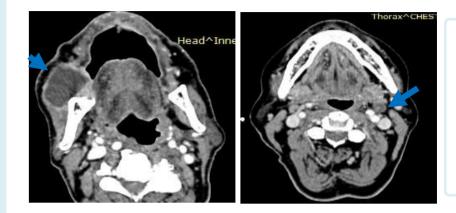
Axial contrast enhancing CT showing metastatic cervical lymph nodes.
